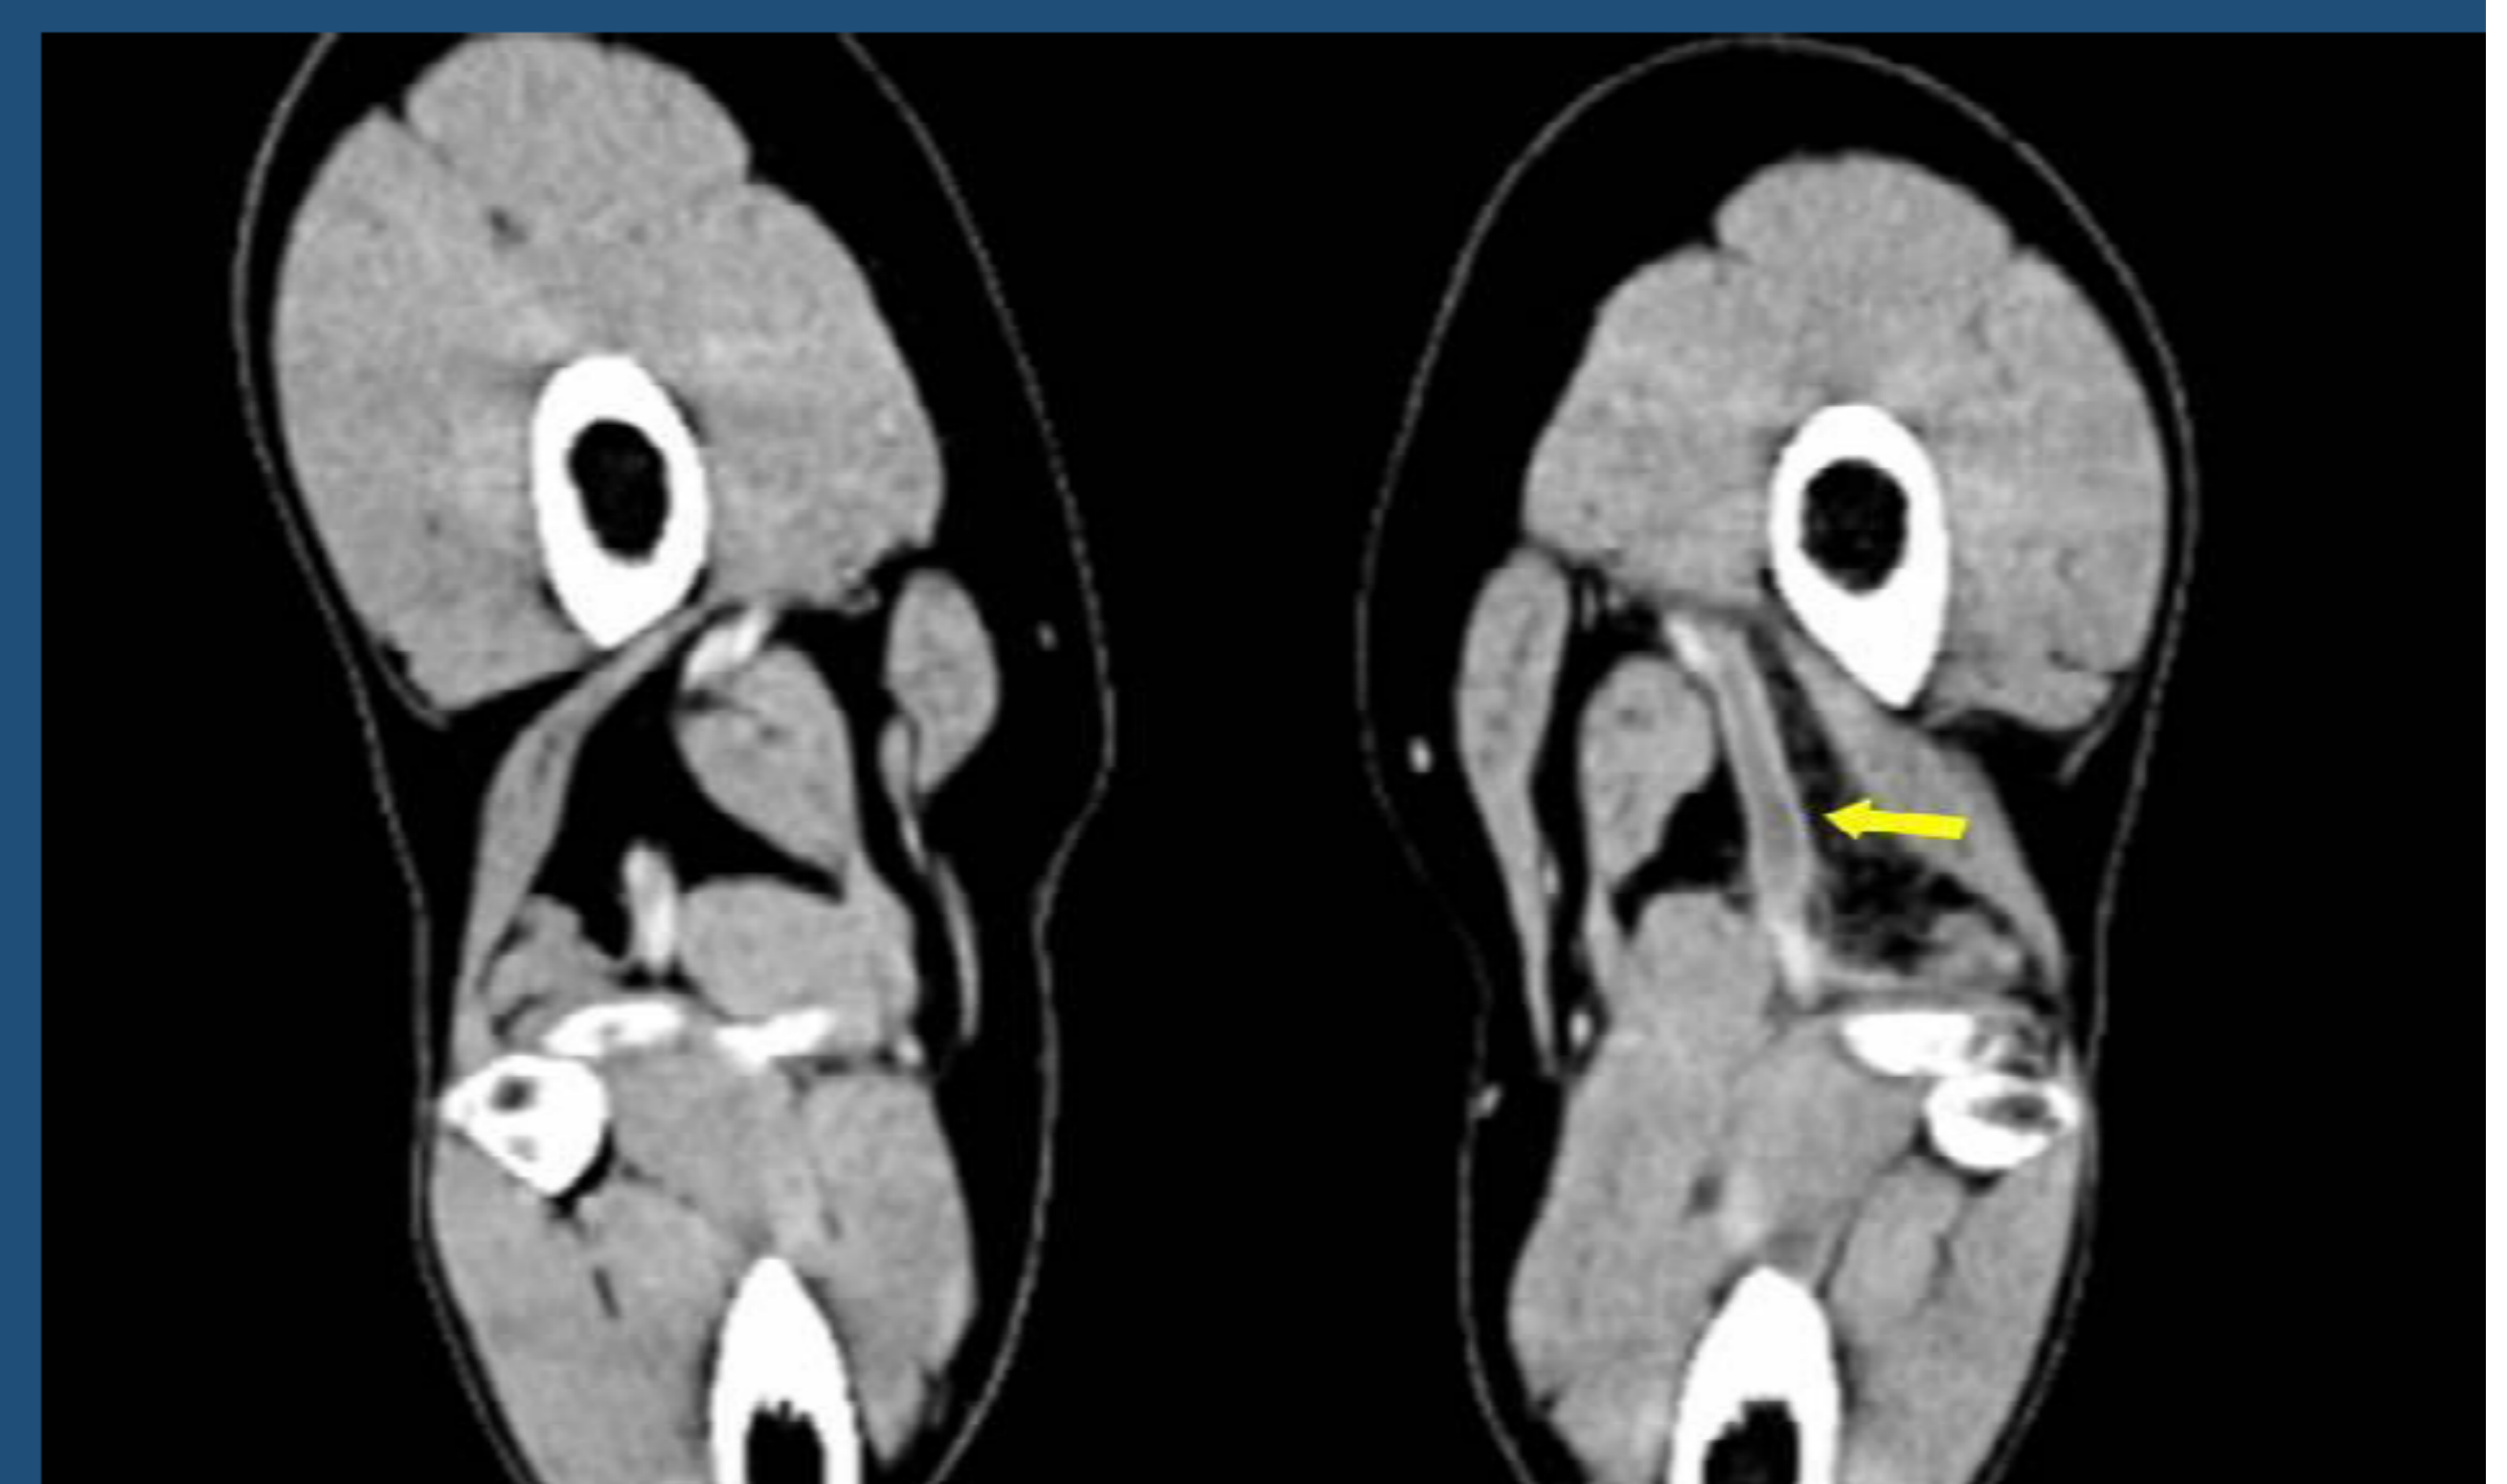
Angio-CT (coronal section): left popliteal vein thrombosis edematous infiltrated adjacent fat
